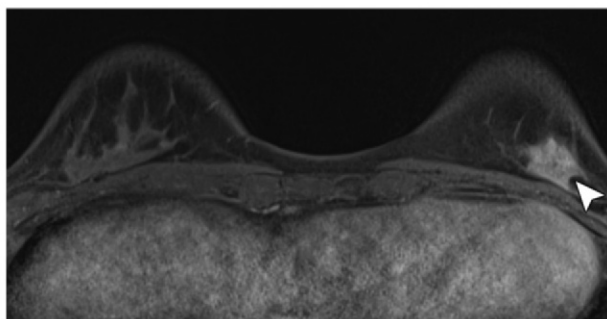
Migratory areas of vascular inflow in a 26-year-old woman with a history of Hodgkin disease treated with mantle radiation. (a) Screening axial contrast-enhanced T1-weighted fat-suppressed MR image obtained in 2010 shows picture framing in the lateral portion of the right breast (arrowhead). (b) Screening axial contrast-enhanced T1-weighted fat-suppressed MR image obtained in 2011 shows picture framing in the posterior portion of both breasts (arrowheads). (c) Screening axial contrast-enhanced T1-weighted fat-suppressed MR image obtained in 2012 shows asymmetric picture framing in the inferior portion of the left breast (arrowhead). The enhancement conformed to tissue planes and diminished at follow-up imaging.
